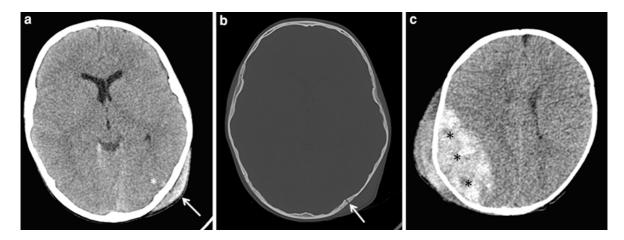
Evaluation of craniocerebral trauma in children: a A 7-year-old-boy with craniocerebral trauma: axial 5 mm image shows extracranial cephal hematoma (*arrow*) and small parenchymal hemorrhagic contusion (*asterisk*). b Axial 5 mm in bone window shows skull fracture line (*arrow*). CTDI vol of cranial CT exam was 25.21 mGy and DLP 473 mGy.cm, which corresponds with a calculated effective dose of 1.89 mSv.
